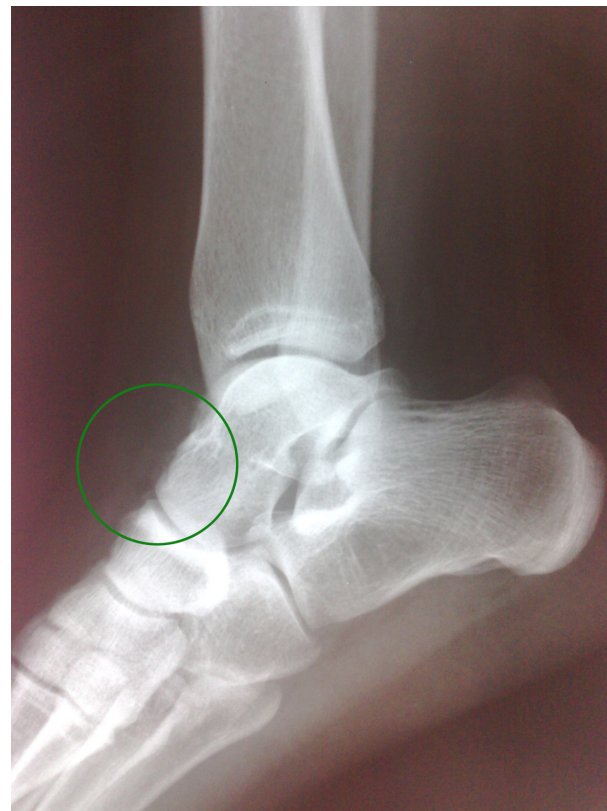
Post-operative radiography of the patients after excision of the lesion to the level of talonavicular joint
